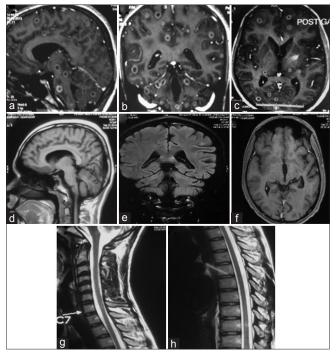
Sagittal, coronal, and axial magnetic resonance imaging $T_{,-}$ -contrast images showed evolution to a ring enhancing lesion with reduction in enhancement after 3 months of treatment (a-c respectively) which showed complete resolution after treatment (d-f). Similar resolution also noted in cervical and dorsal spine (g,h)
